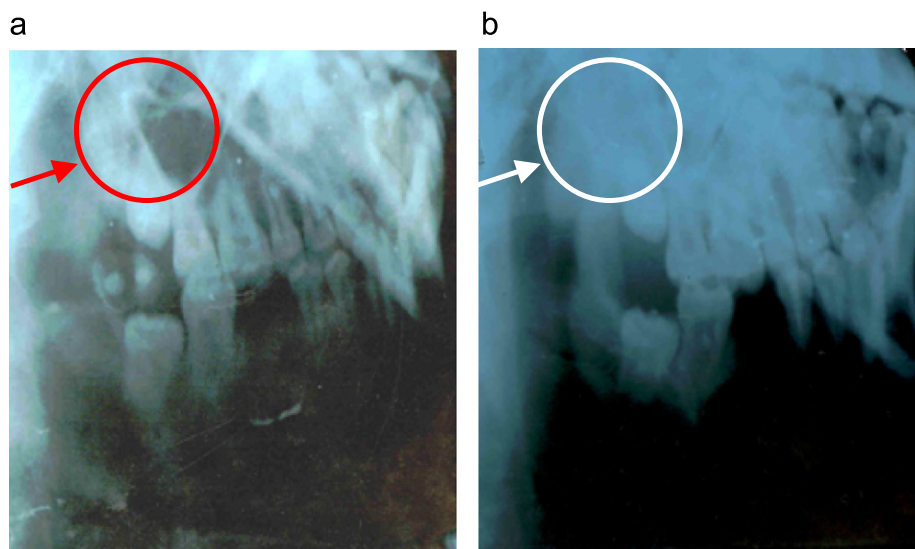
Radiographs of the patient with radicular cyst lesion in maxilla region: (a) before operation and (b) 2 months postoperative.
